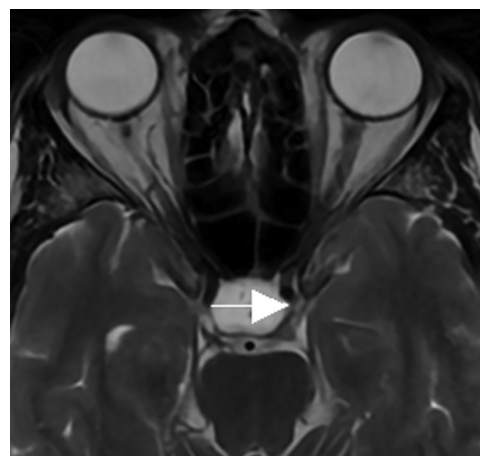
The picture shows the width of the sella tursica in the axial MR image.
